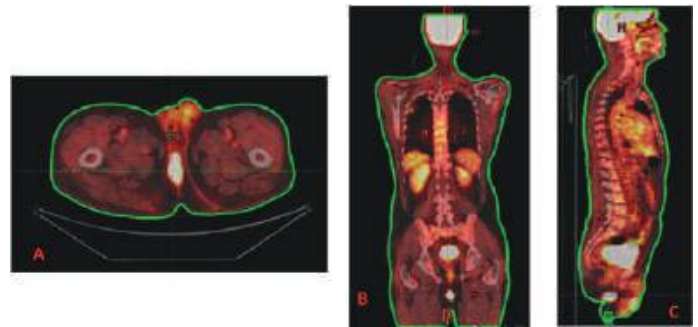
PET-CT showing peri-anal abscess (A) with a lung lesion (B)
